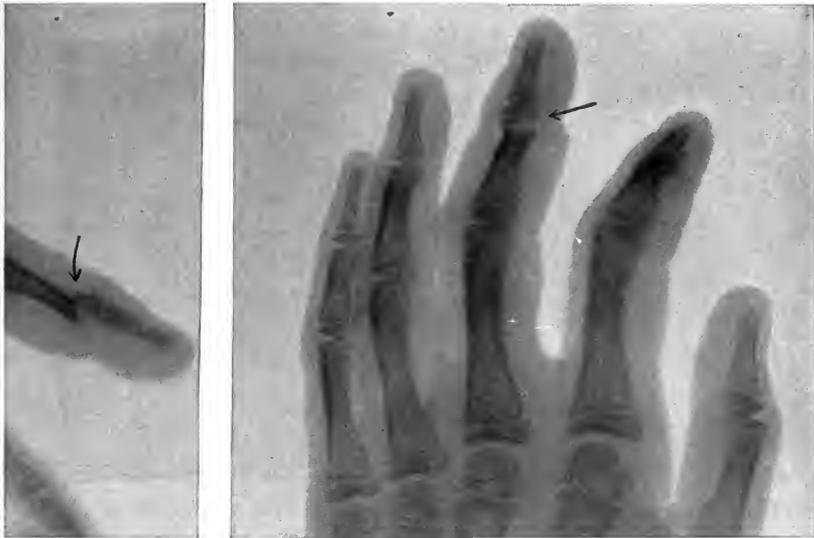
ANTEROPOSTERIOR AND LATERAL X-RAY VIEW OF FRACTURE OF THE SHAFT OF THE SECOND PHALANX OF THE MIDDLE FINGER IN A GIRL OF EIGHT.
